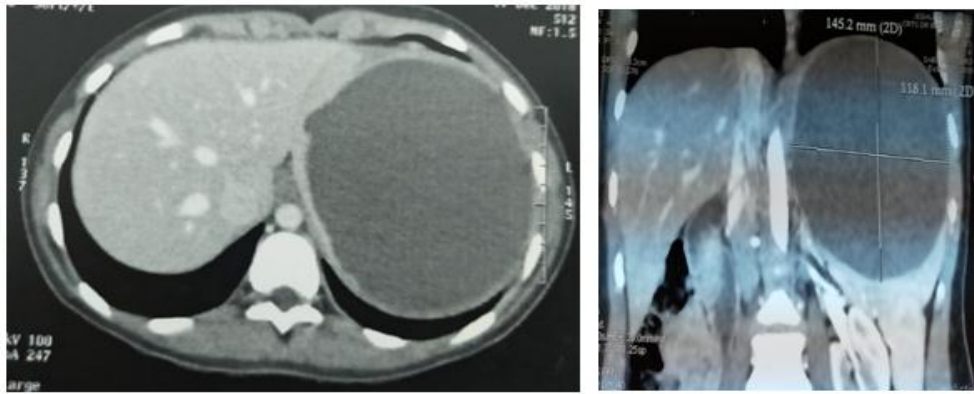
CT: Non-specific in appearance voluminous splenic cyst
